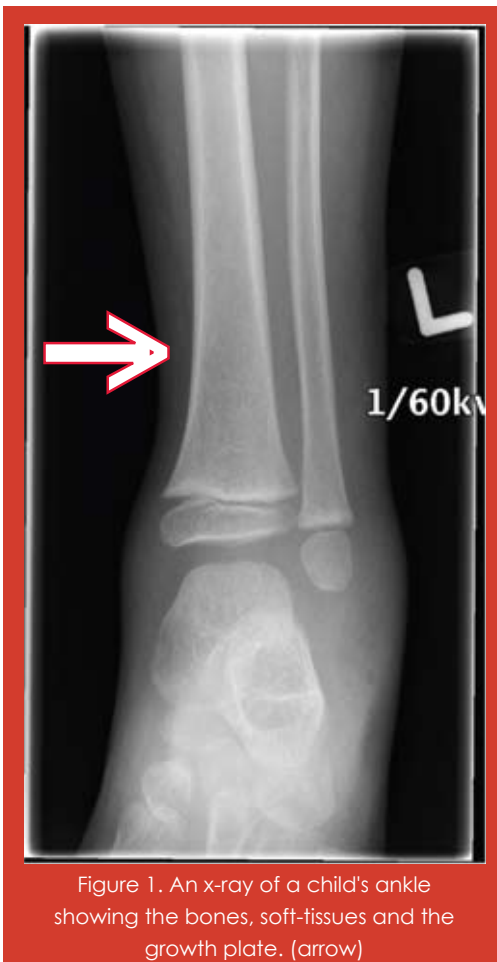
An x-ray of a child's ankle showing the bones, soft-tissues and the growth plate. (arrow)
